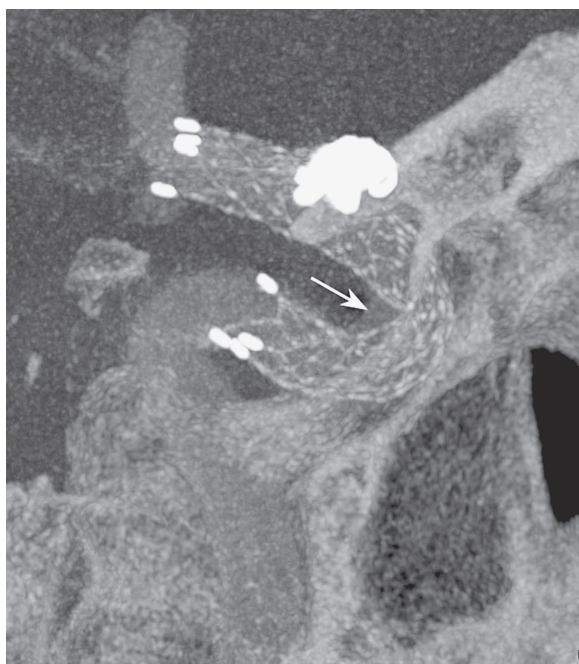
Post-procedure image of the right internal carotid artery reconstructed from flat-panel CT with contrast injection. Note the incomplete apposition of the stent to the vessel wall at the inner curve.
